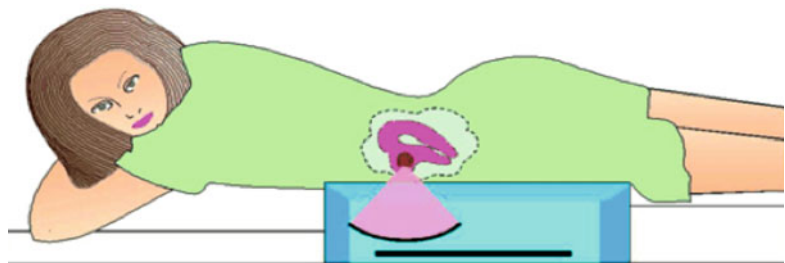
MR-guided focused ultrasound surgery (Courtesy of Insightec, Inc.)
